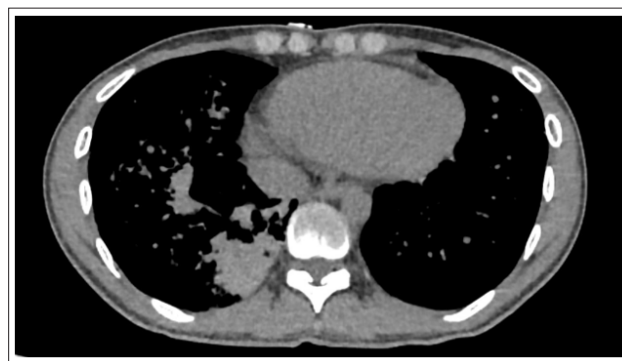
Initial CT scan (Axial Image) of the Chest Showing a Consolidation in the Right Lower Lobe
